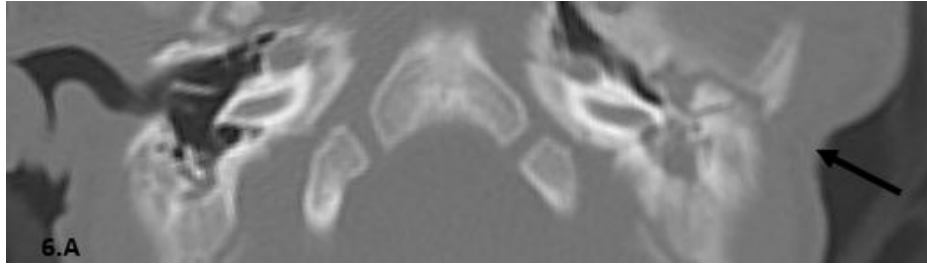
A: Axial CT view, bone window revealed left EAC atresia (black arrow).
